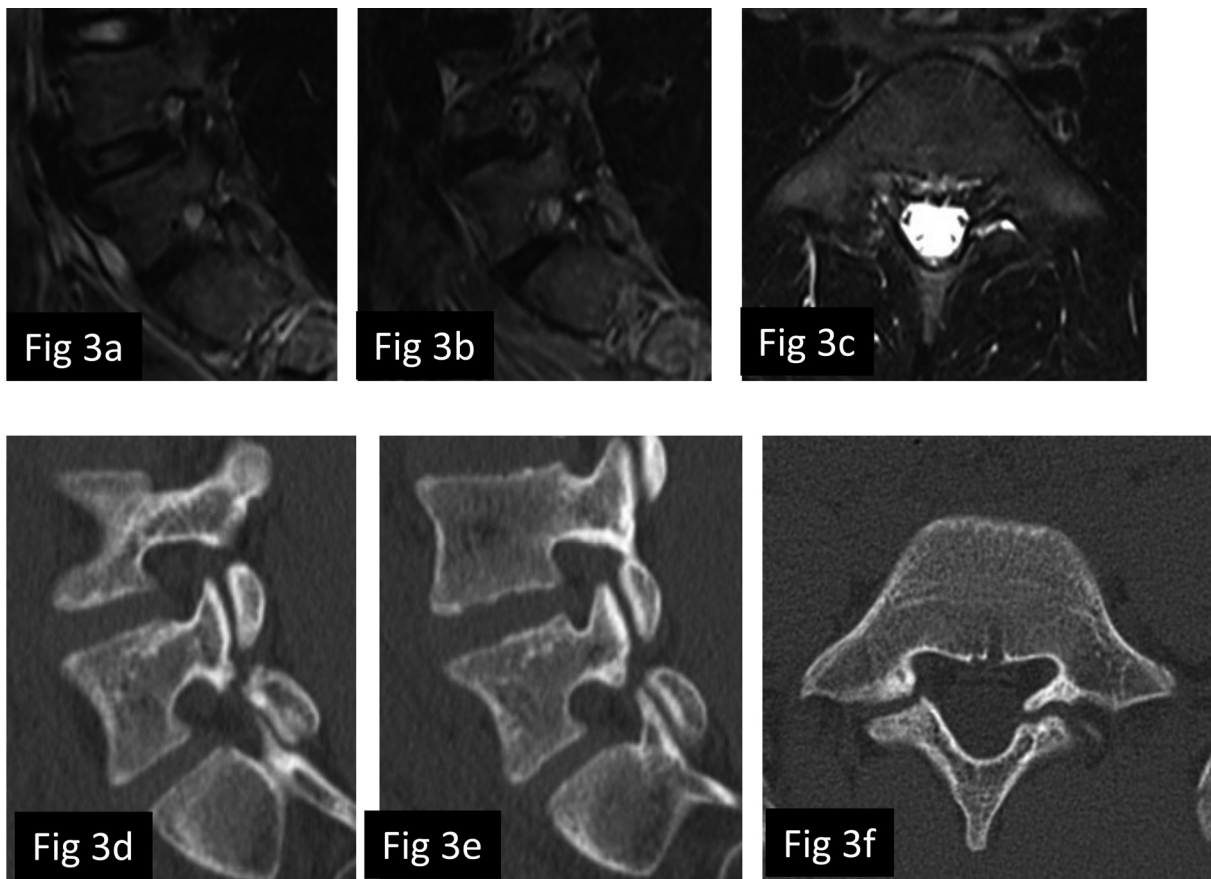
Case 1 after conservative therapy. a–c) MRI STIR showed a low signal, indicating that the bone marrow edema had reduced. d–f) CT showed a complete bony cleft on both sides. MRI STIR, magnetic resonance imaging short-tau inversion recovery; CT, computed tomography. (a and d: sagittal slices on the right, b and e: sagittal slices on the left, and c and f: axial slices on L5.)
